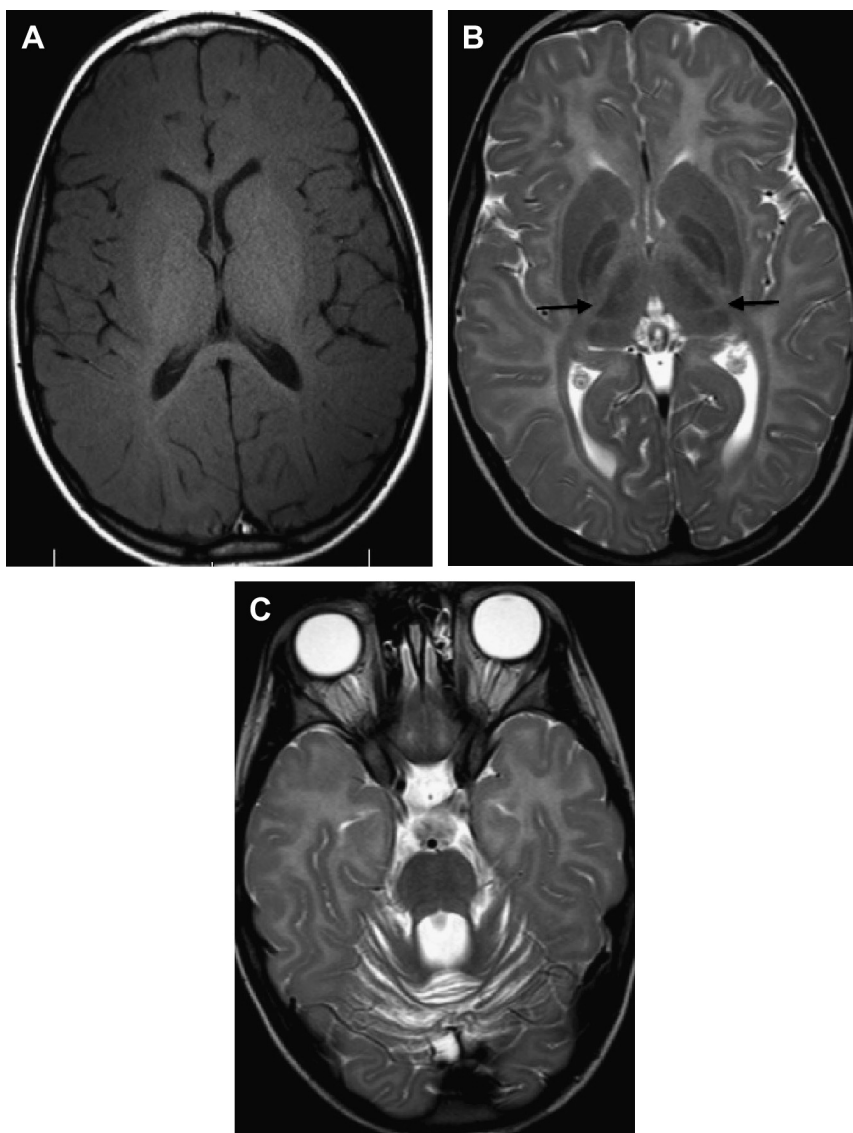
Five-year-old girl with failure of incisor eruption, motor delay, and (subsequently) delayed puberty. Later diagnosed with 4H syndrome. Although there is global delay of myelination, there is myelination of the posterior limb of the internal capsule on axial T1-weighted images (A) and the optic radiations in both axial T1-weighted and T2-weighted images (A, B). There is characteristic hypointensity of the ventrolateral thalamus on axial T2-weighted images (B, arrows) and volume loss of the cerebellum (C). Hypointensity of the globus pallidus is an inconsistent feature for this disorder.
